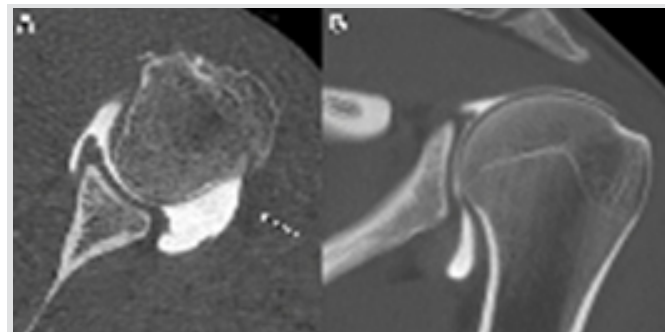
Arthro-computed tomography scan showing no capsular lesion. (a) Axial view: Intact articular capsule (arrow: No contrast dye throughout the joint). (b) Coronal view: Intact inferior articular capsule and supraspinatus.
